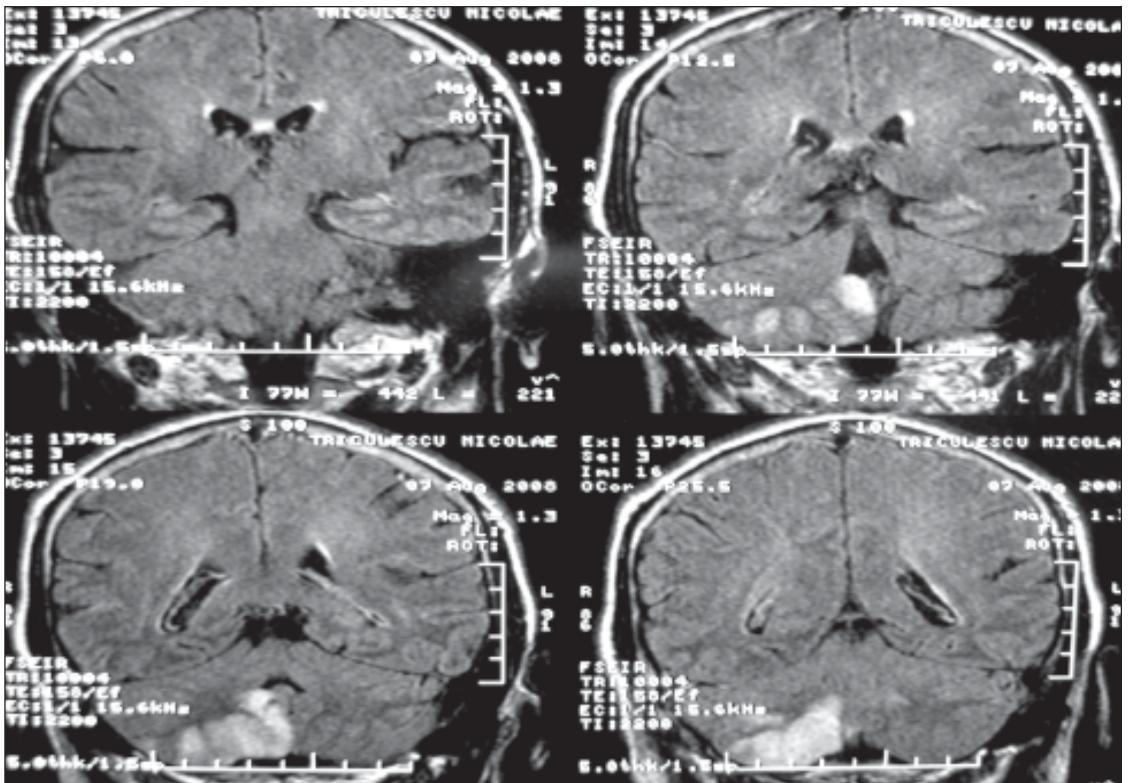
Cerebral MRI – FLAIR image – hyperintense signal localized in the right cerebellum, in the territory vascularized by PICA
